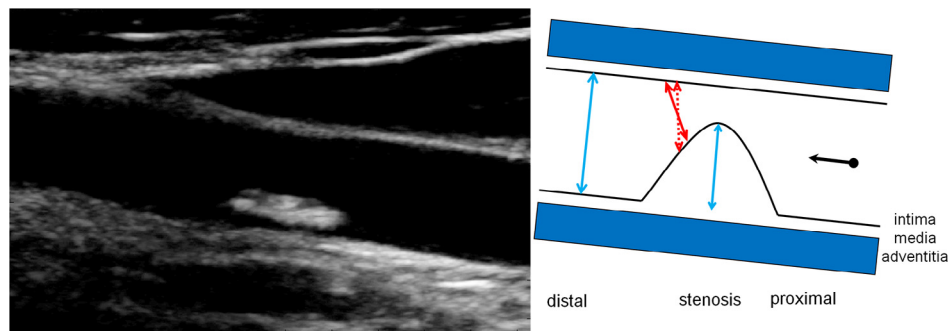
For a B-mode image (left), distances are commonly measured along the ultrasound beam, that is, in the vertical direction. However, in an oblique observation (right), distances will be overestimated (*dashed red arrow*). Rotation of the radial around its center until the shortest distance is reached will reveal the true distance (*solid red arrow*). This will lead to a proper evaluation of the orifice. Note that the degree of stenosis follows from the plaque thickness and unaffected lumen diameter (*blue arrows*). Flow is from right (proximal) to left (distal).
